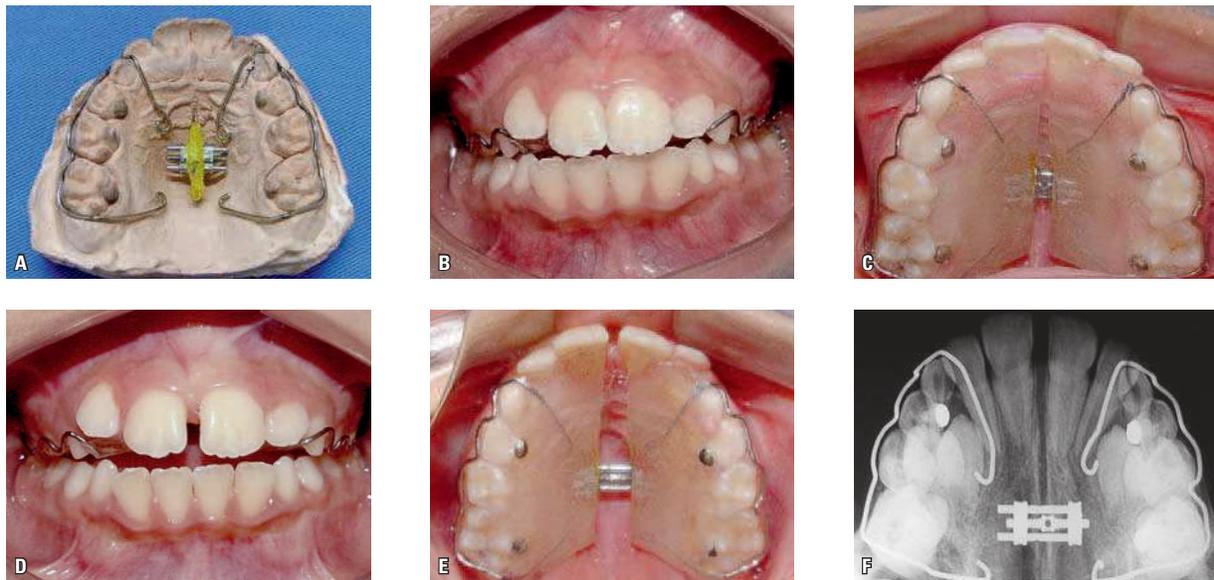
8-year-old girl. Placement of GCS expander with buccal archwire. Activation of 1/4 of a turn in the morning and 1/4 in the evening for 14 days. Incisors were separated; radiograph shows separation of palatal suture.
